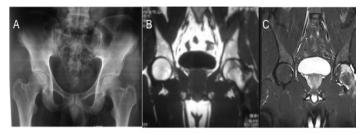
(A)- Plain Radiograph Shows Smaller Left Femoral Capital Epiphysis With Irregularity Of Outline.(B,C) Coronal Mri Images Shows Altered Marrow Signal Of Left Femoral Capital Epiphysis And Neck With Joint Effusion. Final Diagnosis-Legg Calve Perthes Disease
